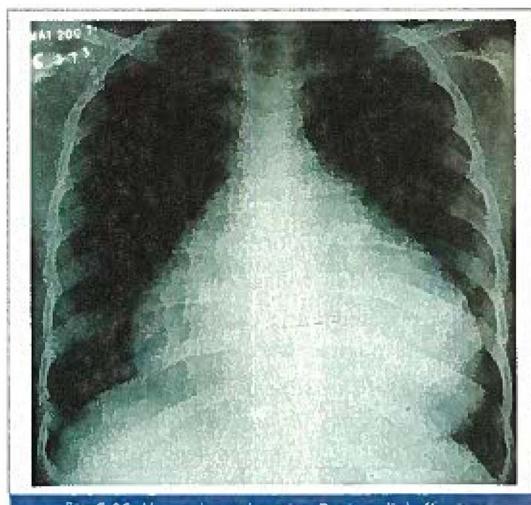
X-ray chest showing Pericardial effusion
